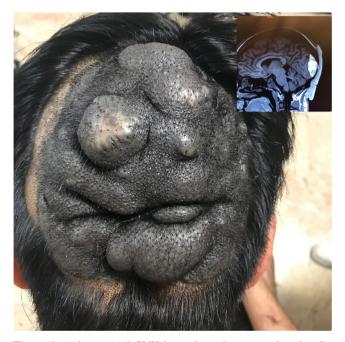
A large-sized CMN located on the occipital scalp of a 20-year-old male. The lesion shows a multinodular component with hypopigmented areas. Cranial MRI venography images reveal a melanocytic lesion with an exophytic component in the occipital scalp with diffuse cutaneous and subcutaneous tissue involvement. The patient has been diagnosed with CNS melanoma with extra-axial melanoma metastasis.
